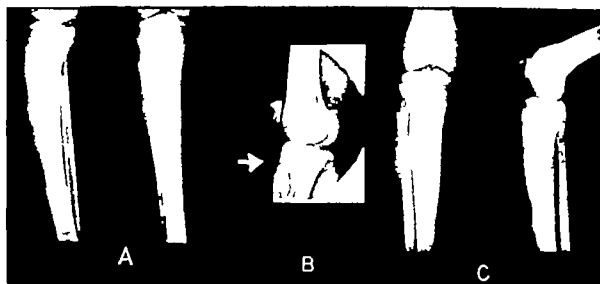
Paget's disease White male, 48 years old. Anteroposterior and lateral views of tibia. (A) Osteoporosis circumscribed area in the upper tibia including the tibial tubercle which is the attachment of this patellar tendon. (B) Avulsion of the tibial tubercle after an ivory peg fixation attempt had failed. Note the separation of the tibial tubercle as indicated by the arrow. The patella is riding high. (C) Postoperative follow up roentgenograms 15 years after fixation of the patellar tendon in a tibial trough. Braided silk suture material was used in this case. The technic is outlined in the text.
